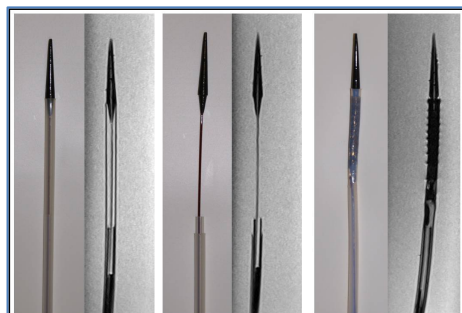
Photos vs. high-res 3D FLASH MRI of the commercially available delivery catheter to screen for ferromagnetic artifacts. Left: delivery catheter without stent; middle: release position without stent; right: delivery catheter loaded with crimped nitinol stent.
